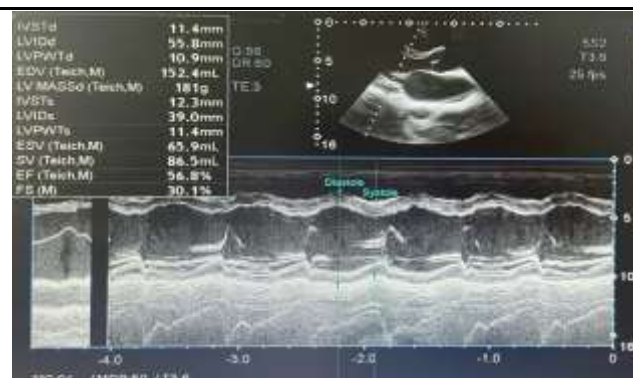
Doppler echocardiography after 6 months: Mild aortic valve regurgitation, moderate 2/4 mitral valve regurgitation, 2/4 tricuspid valve regurgitation, and 2/4 pulmonary valve regurgitation. Pulmonary artery pressure still increased slightly (33 mmHg), and the heart chamber did not dilate. Preserved left ventricular systolic function (EF 56.8%).
